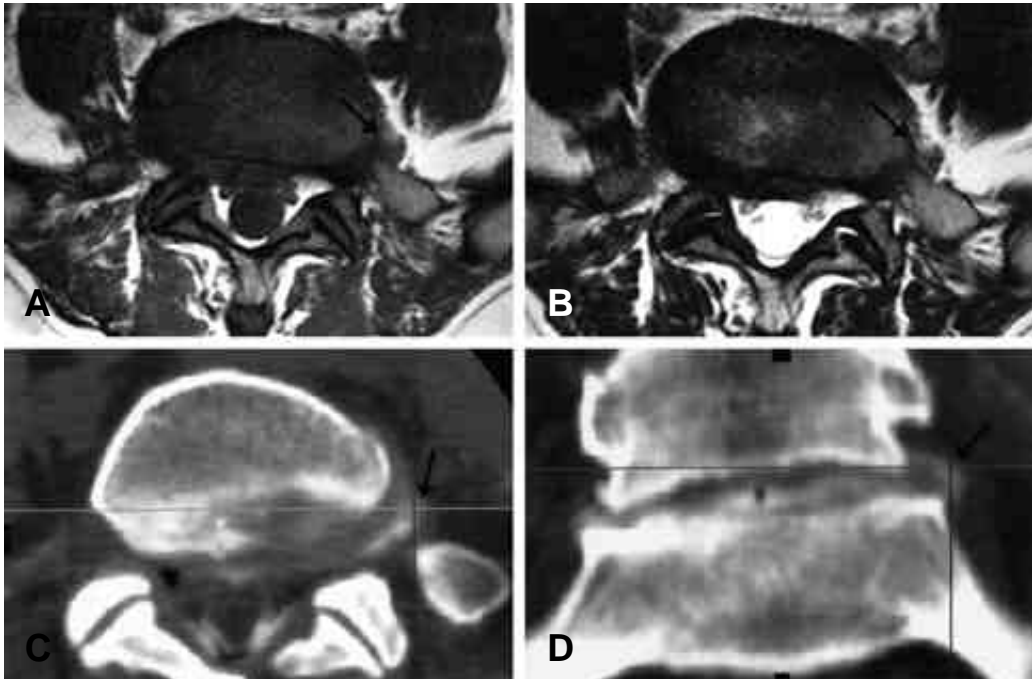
MR and CT scan images of a patient with extraforaminal disc herniation. It was suspected on T1WI (A), T2WI (B) and CT scan images (C), and confirmed with enhanced MR images showing peripheral enhancement (D).
